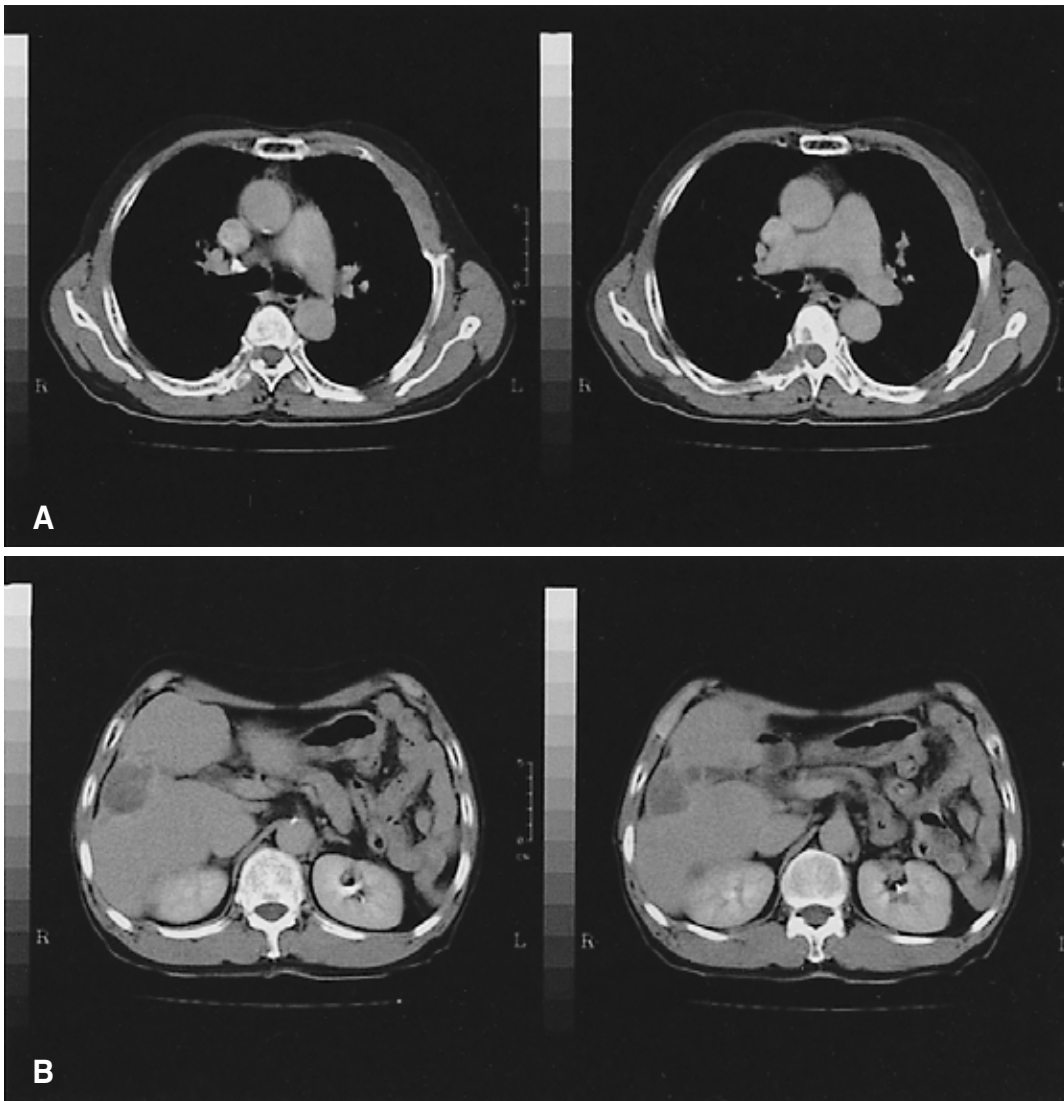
(A) Computed tomography showing a thickened left anterior chest wall but no mass lesion. (B) Computed tomography showing a further decreased hepatic mass lesion compared to previous images.
